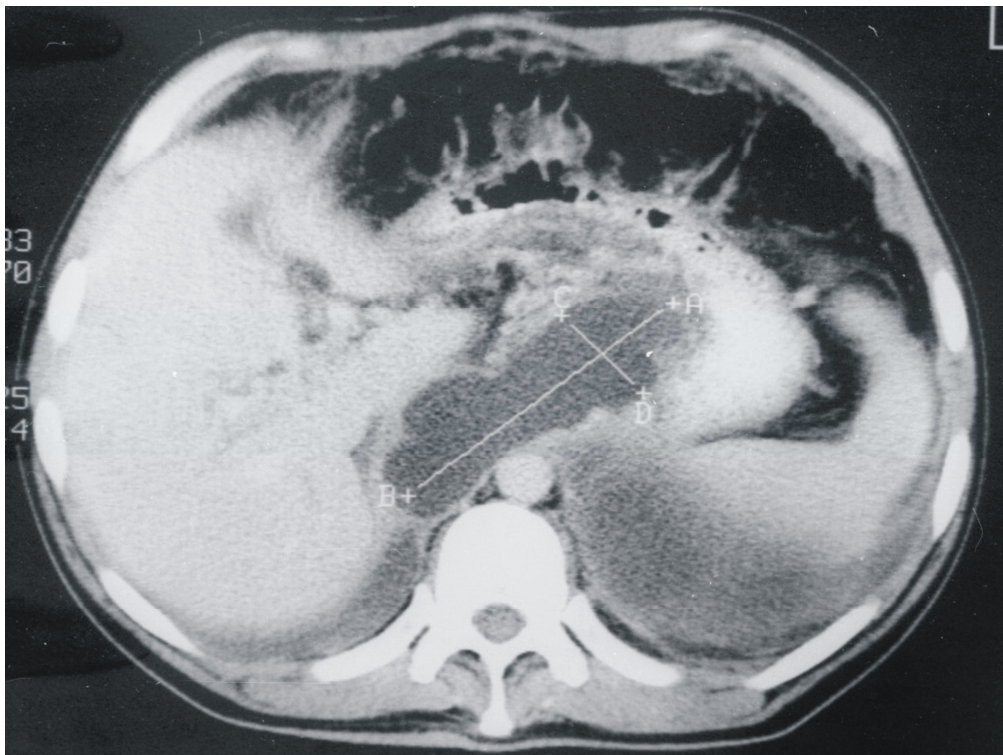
CT Pseudocystic formation is displayed above the pancreatic body, on the more cranial scan fistulous tract can be seen in oesophageal hiatus, bilateral fluidothorax. Circumscribed collections in the left hemithorax.
